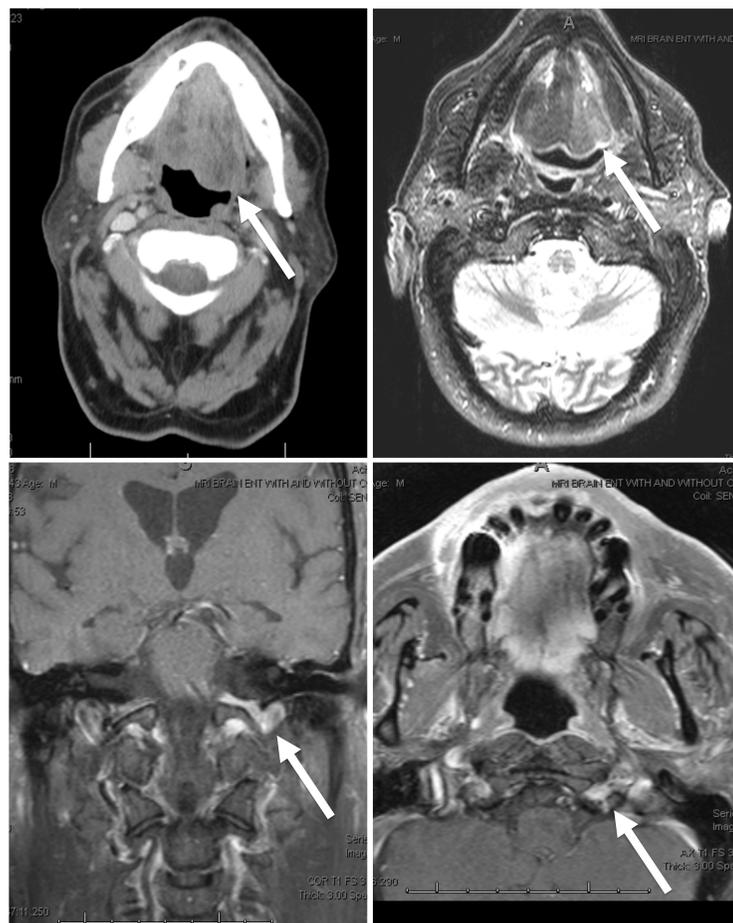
(top left) Axial view of CT scan. Arrow points to asymmetric protrusion of left tongue base into oropharynx. Figure 3 (top right) Axial view of MRI showing T2 phase. Arrow points to denervation atrophy with hyperintense signal of the left hemitongue. Figure 4 (bottom right) Axial view of MRI in T1 post contrast phase. Figure 5 (bottom left) Coronal cut of MRI in T1 post contrast phase. Arrows point to asymmetric enhancement of the left hypoglossal nerve within the canal.
